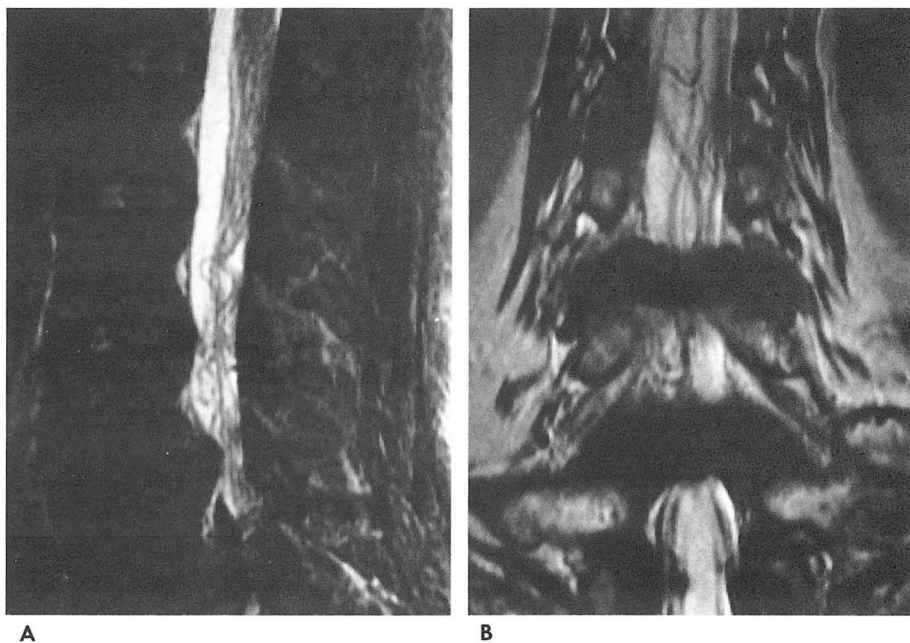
A. T2-weighted sagittal image with fat suppression reveals severe degenerative spinal stenosis at L3-4 and L4-5. Severe RNR are present above the level of stenosis.
